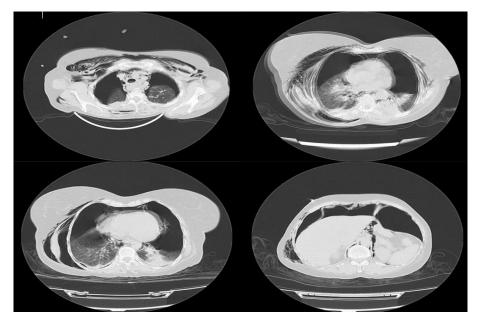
A chest CT of the patient showed severe bilateral collapse of the lung, severe bilateral pneumothorax, pneumomediastinum, pneumoperitoneum, extensive subcutaneous emphysema, and consolidation of the base of the lungs in the context of lung infection or aspiration.
